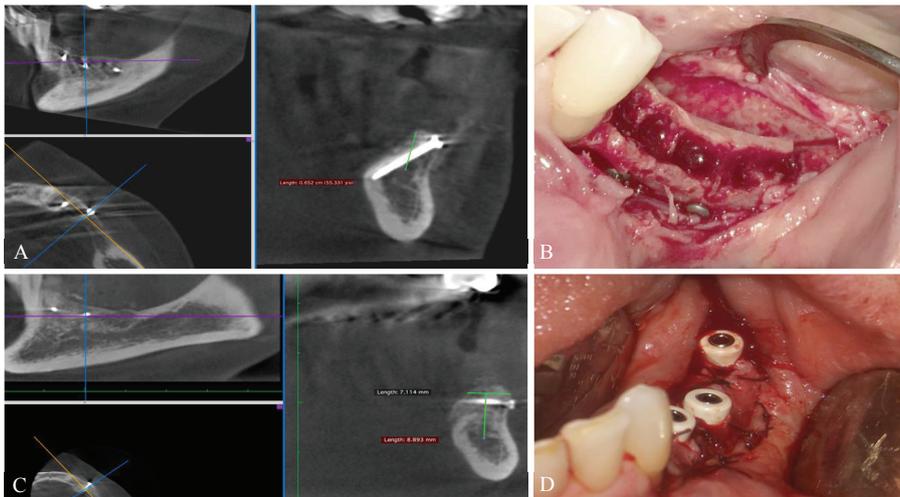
Stages of oral RS: A – CBCT before the operation, multi-planar reformation; B – Stage of operation. Splitting and displacement of the cortical block was performed lingually, fixation with microscrews to the vestibular plate; C – CBCT 3 months after reconstruction, multi-planar reformation; D – Stage of implantation: implants and healing abutments are placed, mucous membrane flap is displaced apically and fixed with sutures
